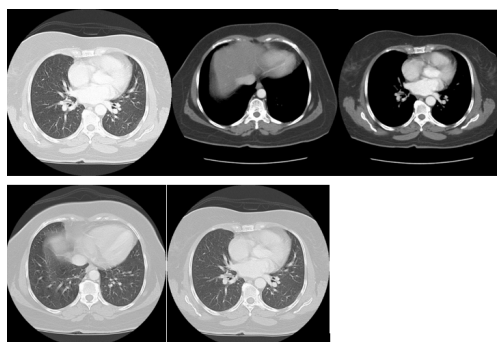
CT AFTER (Same cuts has to be included)
